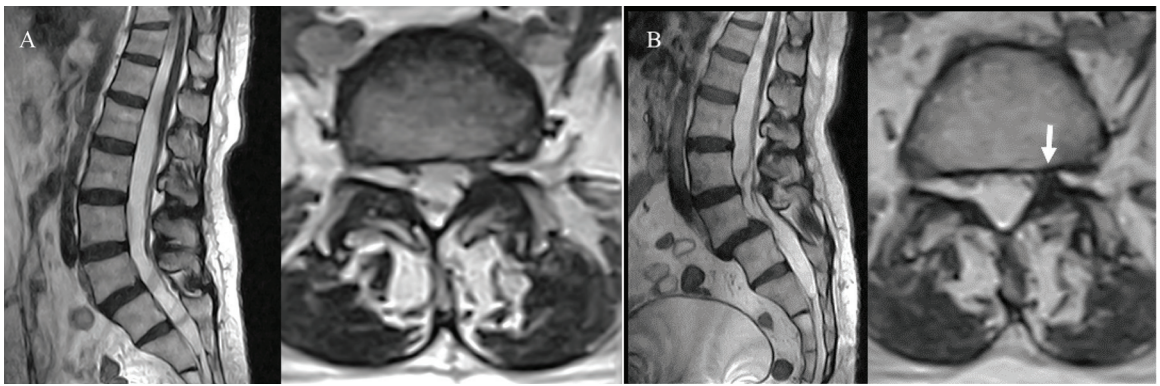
Sagittal and axial HYCE MRI in supine position (A) and weight-bearing position (B) of a 55-year-old female patient with back pain radiated to left leg. There is progression of spondylolisthesis at level of L5/S1 from grade 1 in supine position to grade 2 in weight-bearing position, with progressive left L5 traversing nerve root compression (white arrow in B).
